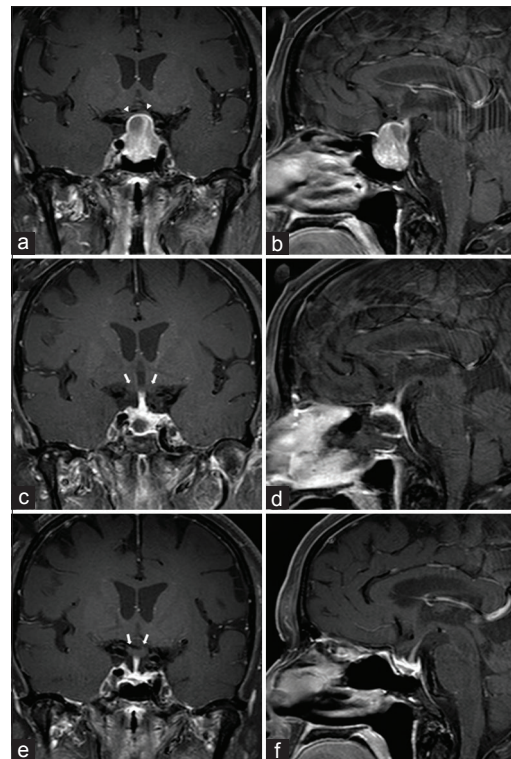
A 71-year-old female who developed progressive vision loss in the left eye over 6 months. Because of her worsening vision she underwent a brain MRI with gadolinium (a and b) revealing a $24 \times 19 \times 16$ mm sellar mass with suprasellar extension. The chiasm was markedly compressed (white arrowheads). The normal gland was thinned and pushed superiorly toward the right. Formal neuro-ophthalmologic visual field testing confirmed severe global decreased acuity in the left eye, and a superior temporal quadrant defect in the right eye. Her preoperative prolactin level was 41.5 ng/ml indicating the tumor was not a prolactinoma. The patient underwent endonasal endoscopic tumor removal. The patient's immediate postoperative MRI (c and d) and 1 year postoperative MRI (e and f) revealed a GTR of the tumor and decompression of the optic apparatus (white arrows)
